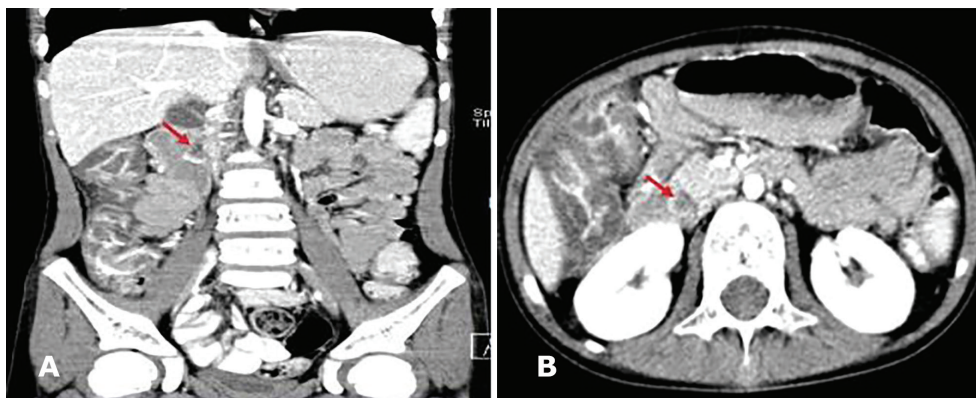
(A and B): Coronal and axial images of abdominal CT scan with IV and oral contrast show wall thickening and mural ulcerations of ascending and transverse colon along with symmetric bulging and thickening of duodenal papilla (Arrow).
